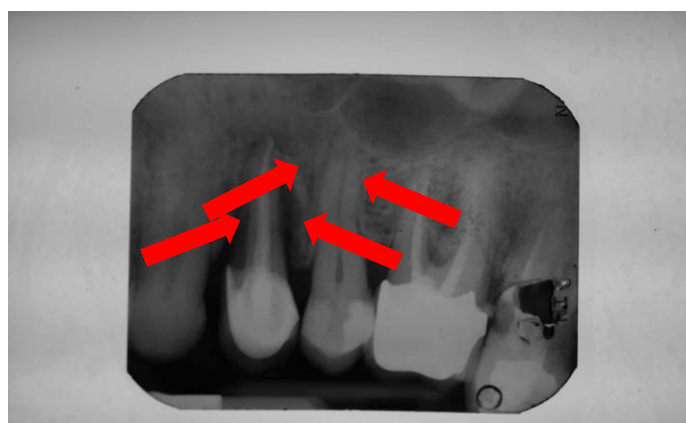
One-year follow-up X-ray: further bone regrowth and lengthening of the medial bony papilla (arrows) can be seen.
